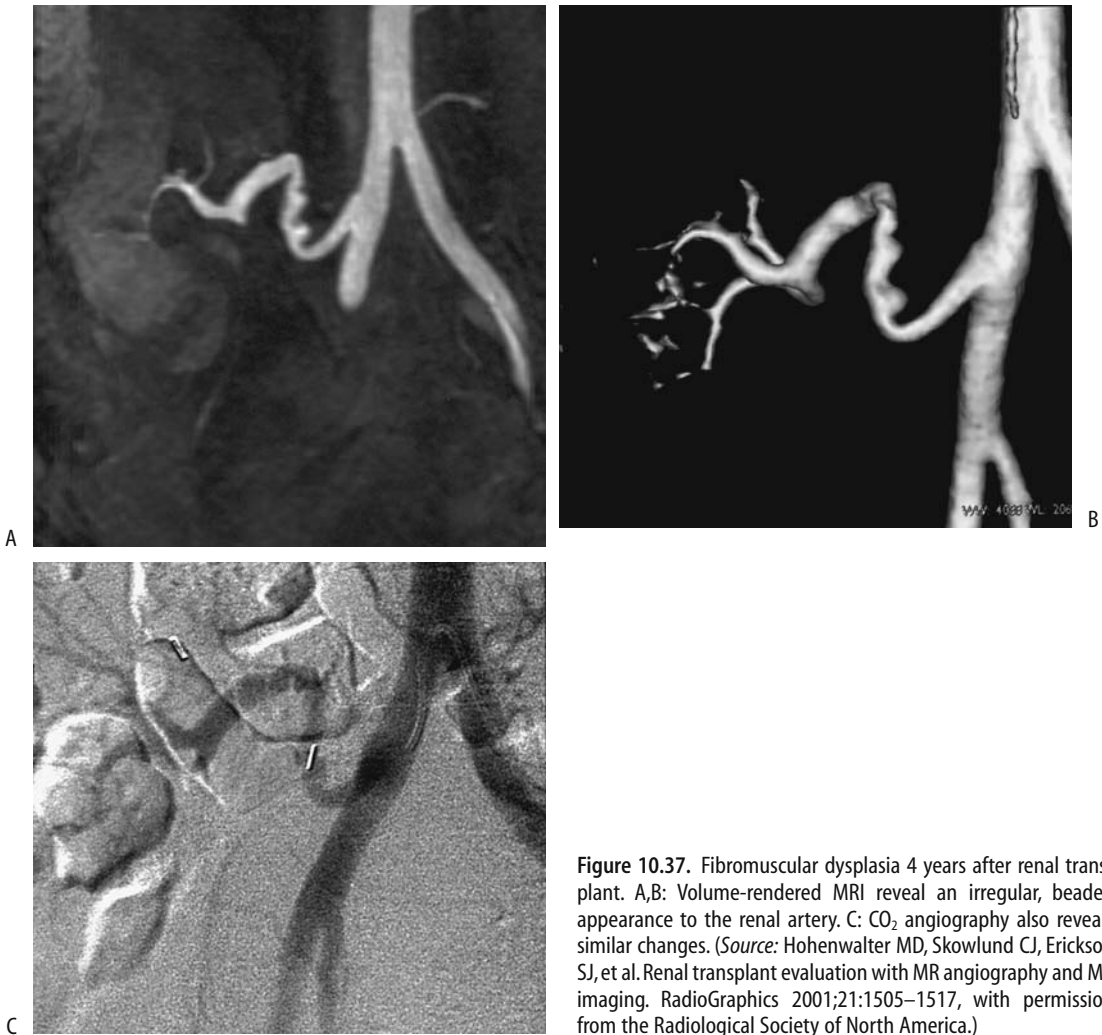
Fibromuscular dysplasia 4 years after renal transplant. A,B: Volume-rendered MRI reveal an irregular, beaded appearance to the renal artery. C: CO₂ angiography also reveals similar changes. (Source: Hohenwarter MD, Skowlund CJ, Erickson SJ, et al. Renal transplant evaluation with MR angiography and MR imaging. *RadioGraphics* 2001;21:1505–1517, with permission from the Radiological Society of North America.)
